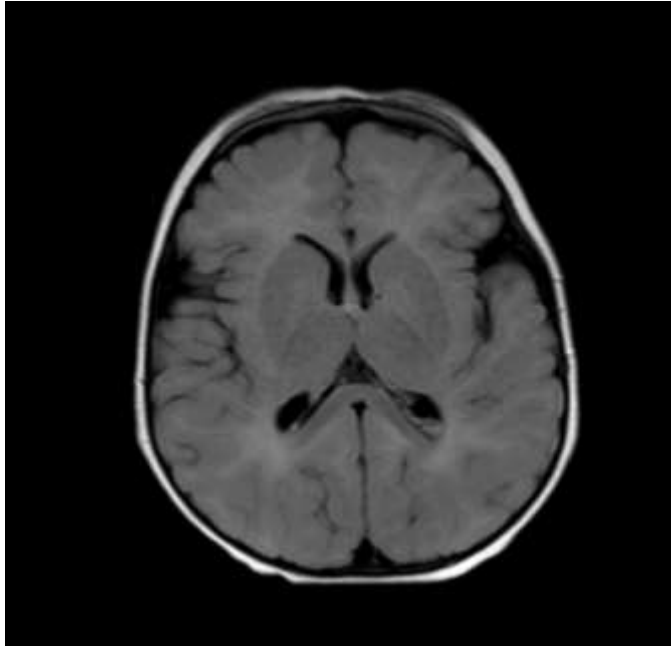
Axial MRI brain and temporal FLAIR-long TR image for patient number 8 shows dysmyelinating disorders.
